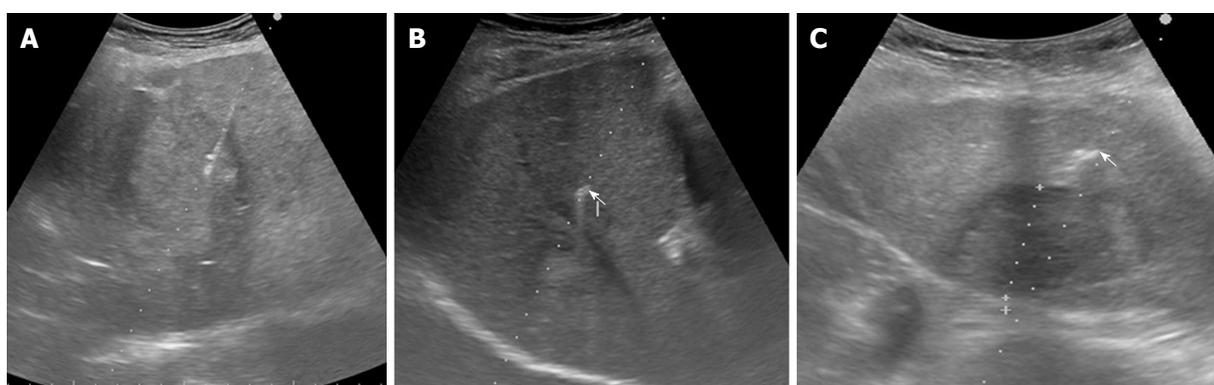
Ultrasonography-guided fiducial placement. The two different gold markers are sonographically undistinguishable. A: Needle delivering fiducial into a liver mass; B: Hyperechoic flexible wire notched gold marker, 0.28 mm × 10 mm, Gold Anchor marker (arrow) near a liver mass; C: Hyperechoic Grain cylindrical gold marker, 1 mm × 4 mm (arrow) near a liver mass.
